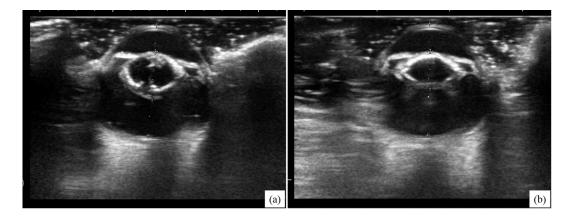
Preoperative ultrasound examination findings of right eye (a) and left eye (b). High echo density was detected in the entire lens in both eyes. The ocular axial length was 15.2 mm for both right eye and left eye, and lens thickness right eye and left eye was 5.2 and 5.1 mm, respectively.
